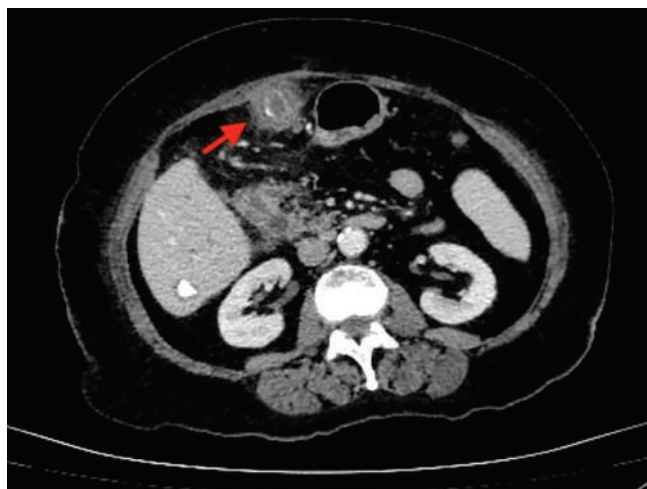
Axial contrast-enhanced abdominal computed tomography demonstrating a subcutaneous abscess in the anterior abdominal wall with peripheral contrast enhancement and a centrally located hyperdense calcified focus (red arrow), consistent with a retained gallstone.
